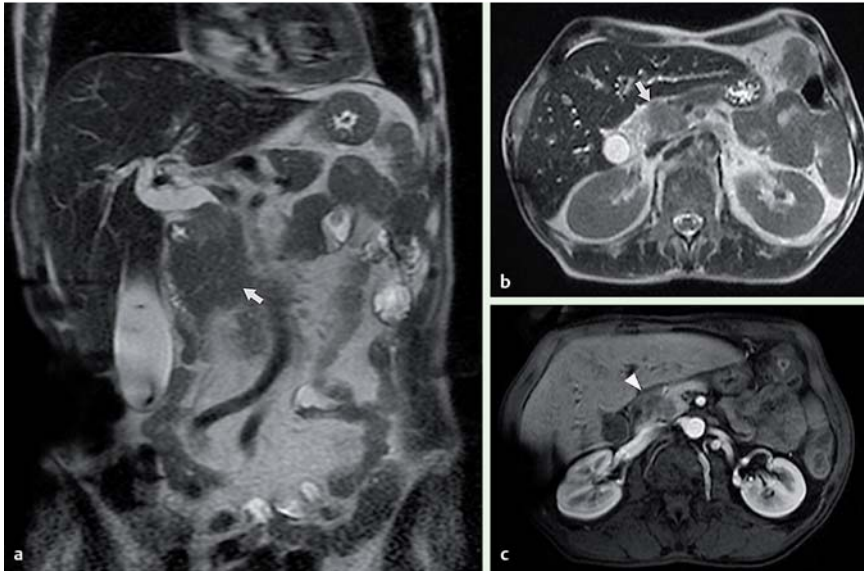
Magnetic resonance imaging (MRI) in a 52-year-old man with obstructive jaundice and a known meningeal hemangiopericytoma showing biliary duct dilatation, an enlarged gallbladder and a heterogeneous mass in the pancreatic head, which appeared: a, b hypointense on T2-weighted fast-spin echo images (arrows) in coronal and axial views; c hypovascular during the arterial phase of a contrast-enhanced T1-weighted gradient echo image (arrowhead).
